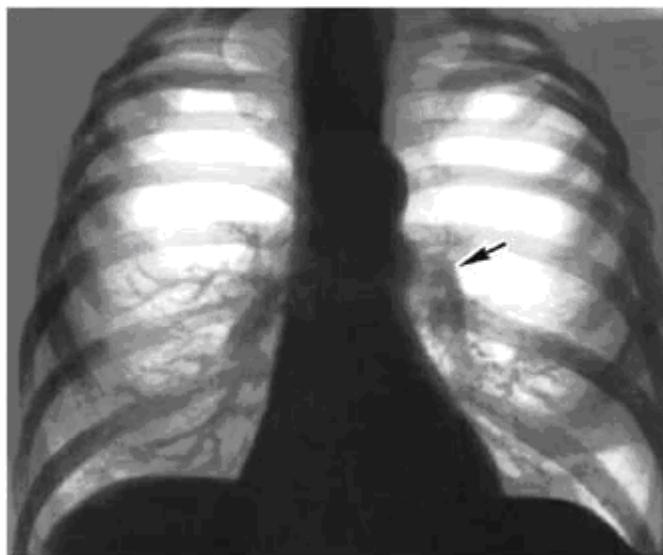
X-ray of the chest cavity of a patient with pulmonary emphysema and CHD: the heart is relatively small, the pulmonary cone arch (indicated by the arrow) is enlarged, the roots are enlarged due to large branches of the pulmonary arteries, and the peripheral vascular pattern of the lungs is depleted.
